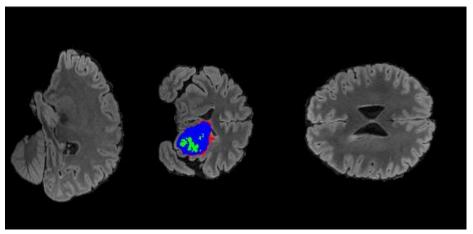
MRI Scan with annotated segmentation label
